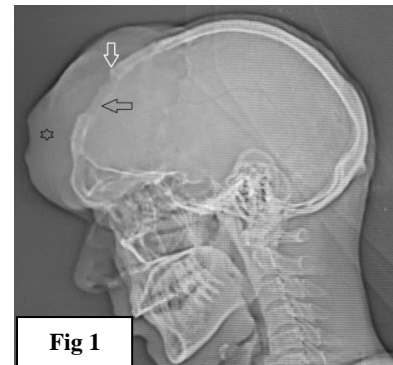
Skull X-ray lateral view showing soft tissue swelling at frontoparietal region (black star) and causing destruction of the underlying bone (horizontal black arrow). Transition zone is well demarcated (vertical white arrow).
